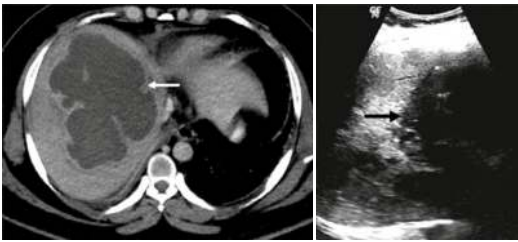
Liver abscess. Contrast-enhanced CT shows a large, coalesced macroabscess in the liver (arrow)
